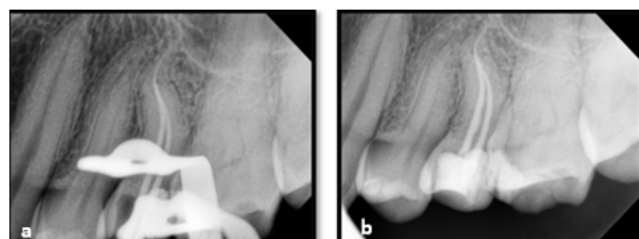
a:) Master cone radiograph, b:) Post obturation radiograph of 25.
